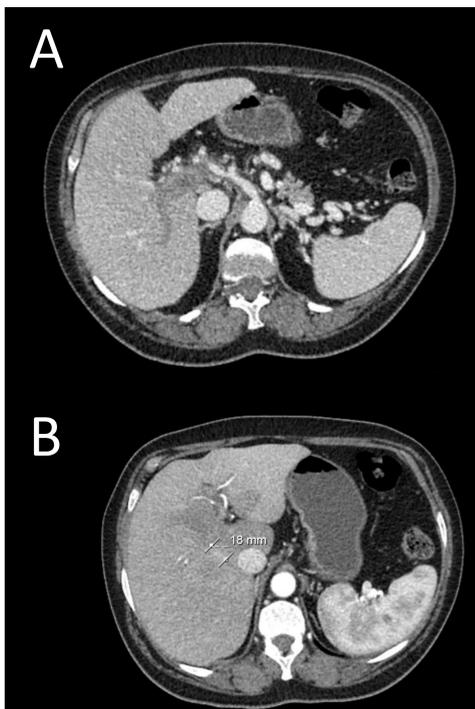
Abdominal-CT findings
